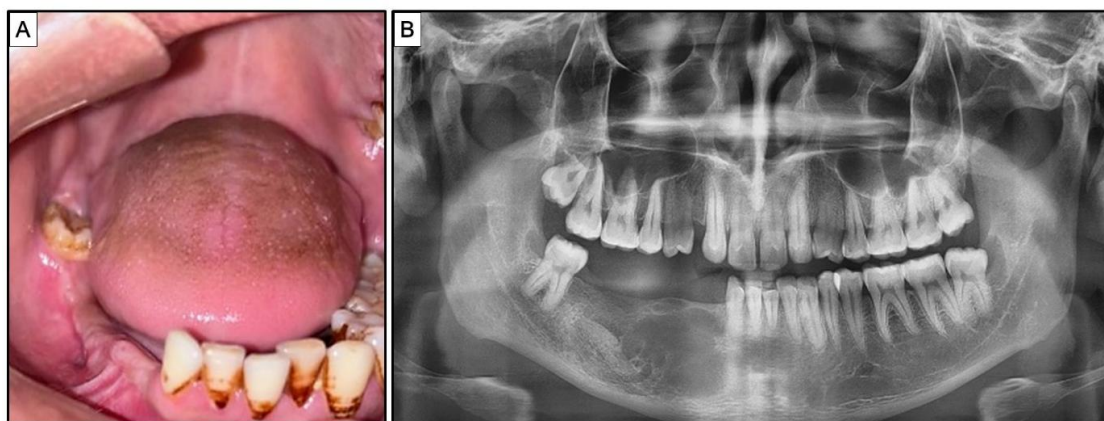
Adequate healing observed at 6-month follow-up on A) Intraoral examination and B) Orthopantomogram
